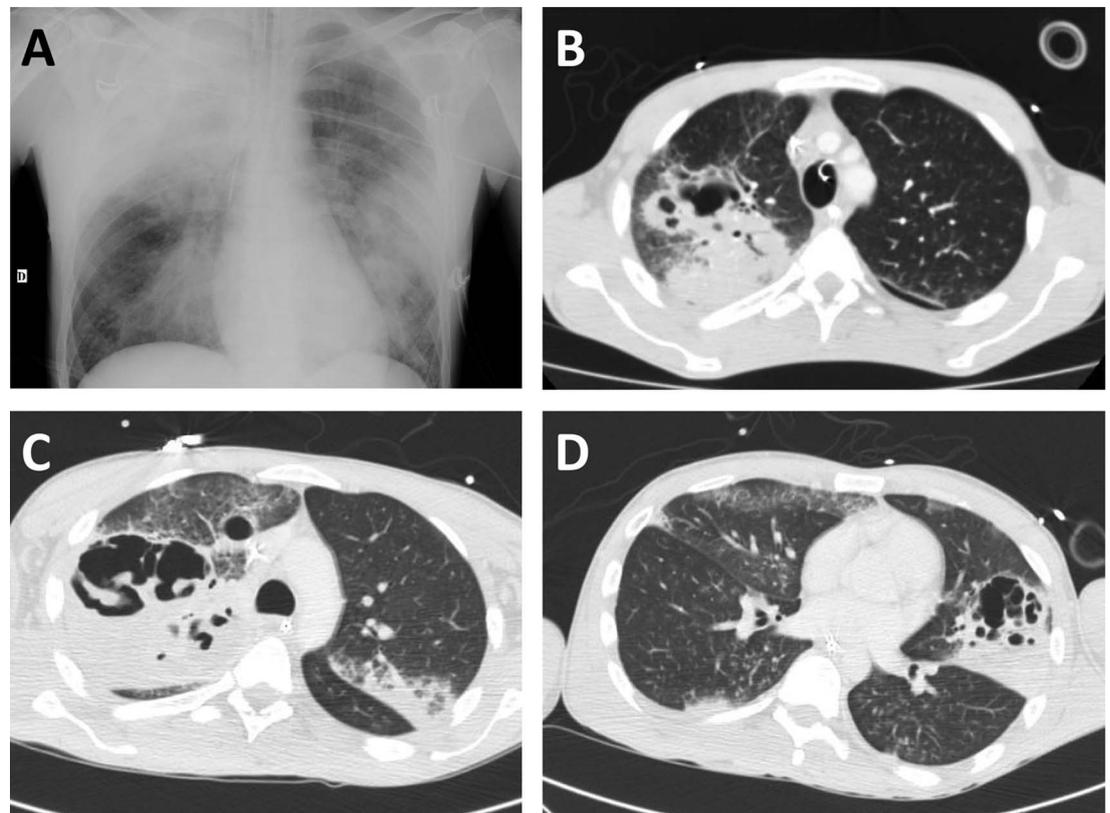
Chest X-ray (A) and thoracic CT scan (B, C and D) showing bilateral necrotising pneumonia complicating A(H1N1) influenza infection due to PVL-positive *Staphylococcus aureus*.
